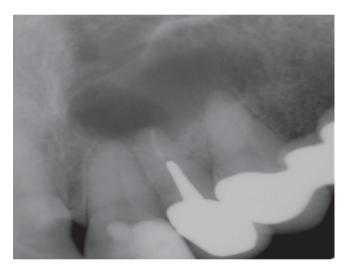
Periapical radiograph showing periapical radiolucency involving previously root canal treated tooth
